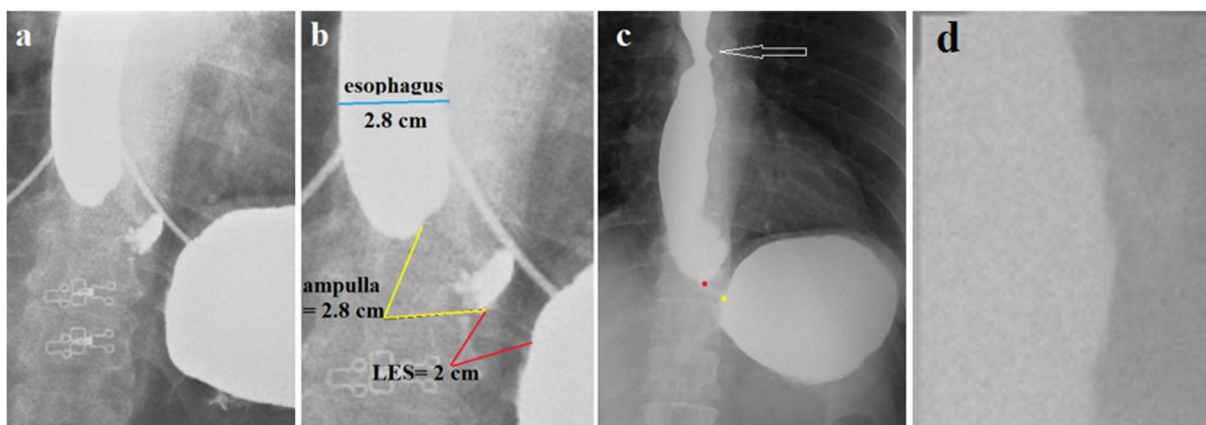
Case 2. (a) The radiograph of EGJ with high gastric pressure at age 63. (b). Scheme to figure (a). The width of the esophagus is 2.8 cm. The length of the LES is 2 cm. XIR = 1.4. (c). At the age of 65. The width of the esophagus is 3.2 cm, and the LES length (distance between colored dots) is 1.4 cm. XIR=2.3. In the upper part of the esophagus, an asymmetric narrowing is visible, suspicious of an ulcerative process (arrow). (d) The left wall of the esophagus has a finely wavy contour.
